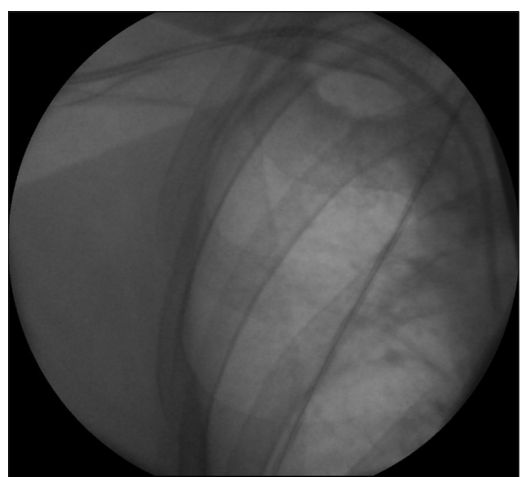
Chest radiograph showing properly positioned catheter
